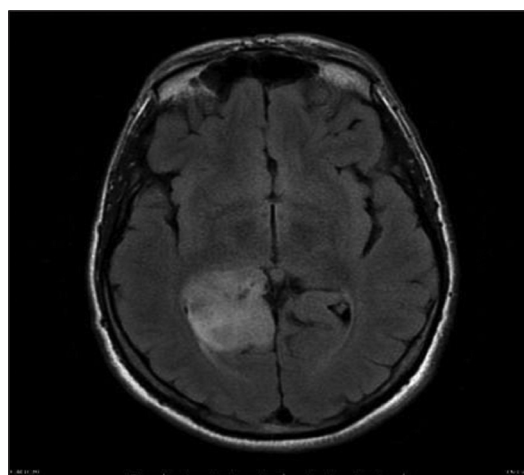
Magnetic resonance imaging of diffuse astrocytoma Grade II
